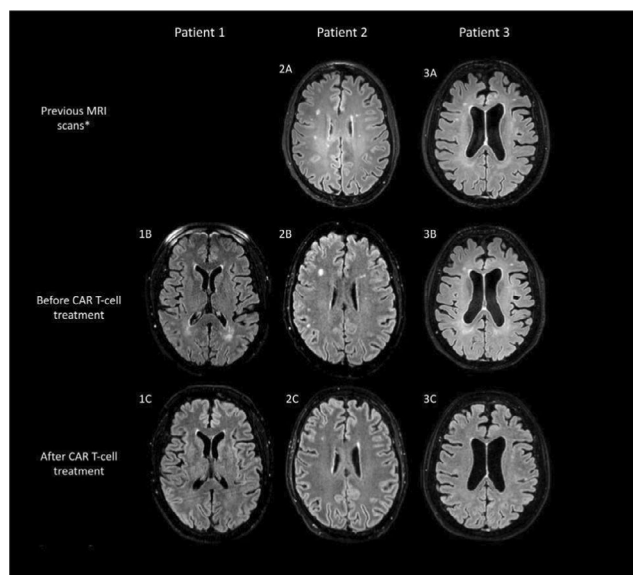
Axial MRI FLAIR of patients 1 to 3. “A” and “B” show subcortical white matter hyperintensities (WMH) in scans prior to CAR T-cell treatment. “C” shows the disappearance or decrease in size of the same WMHs, after CAR T-cell infusion.
